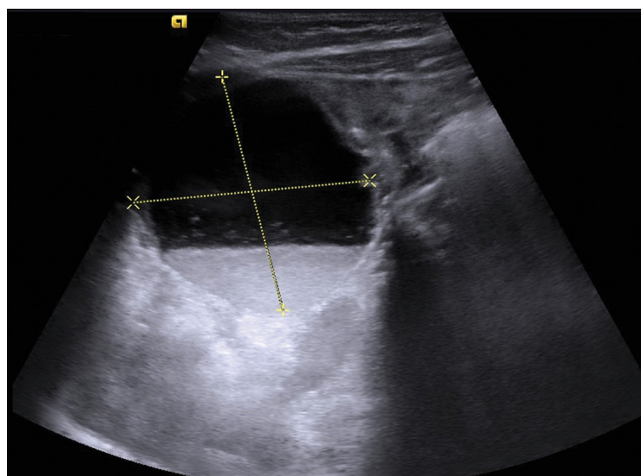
Postnatal ultrasonographic scan showed a complex ovarian cyst of 40x39 mm in diameter containing fluid-debris level and suggested haemorrhage and/or torsion
